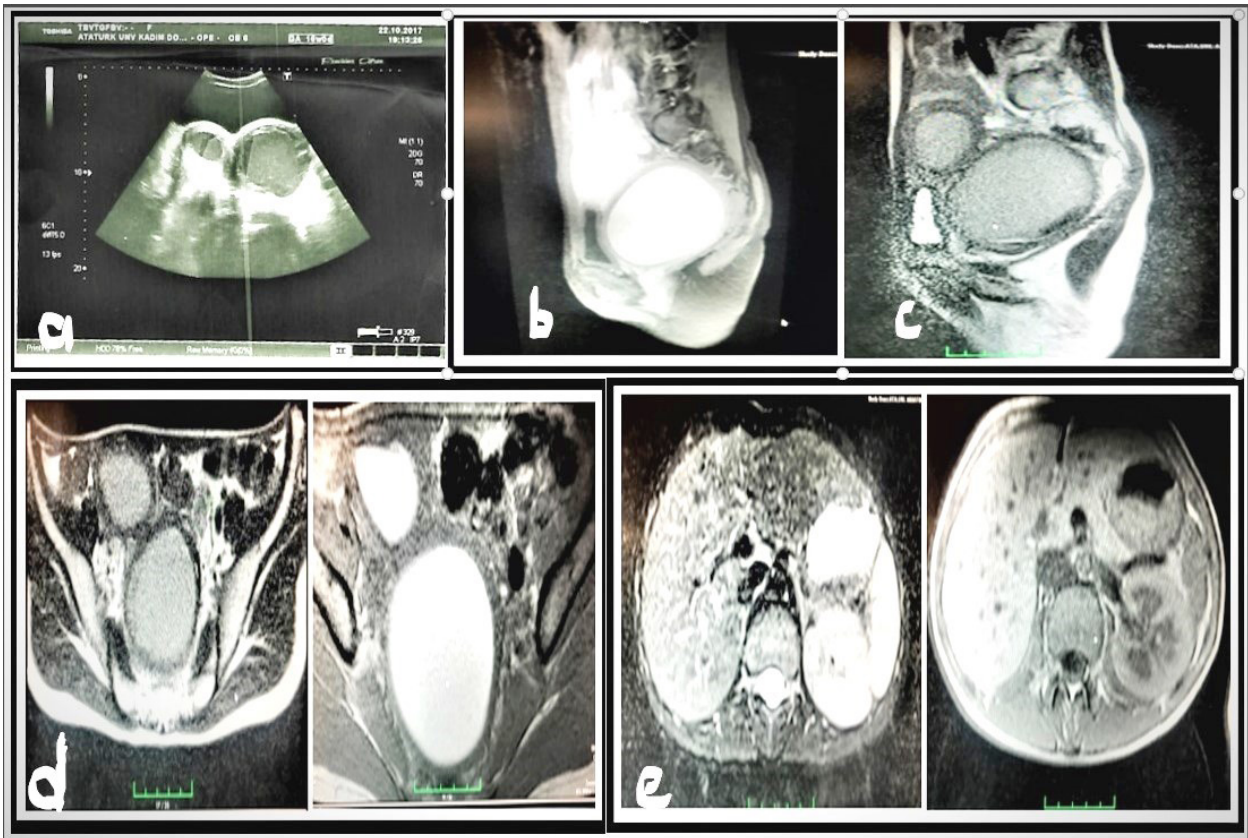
Hematometra appearance of the uterus in transabdominal USG Figure 1b-c: Hematometra appearance in pelvic magnetic resonance imaging on sagittal plane Figure 1d: Uterus didelphys and dual cavity appearance in pelvic magnetic resonance imaging on axial plane Figure 1e: The right renal agenesis and enlarged enlargement of the left kidney (11*6*6 cm) were seen in pelvic magnetic resonance imaging on axial plane.
